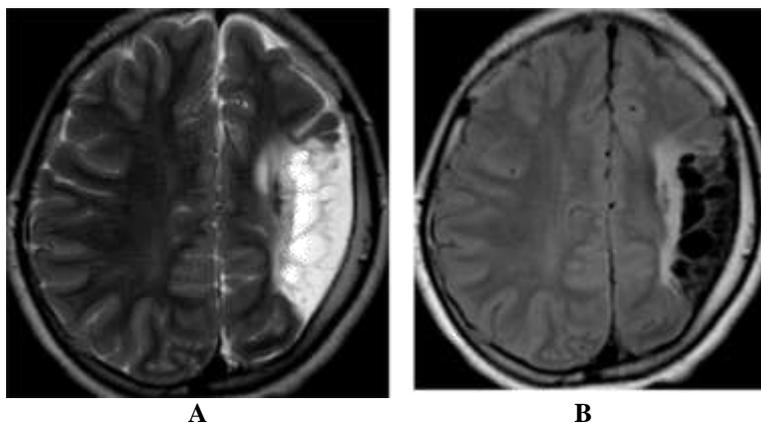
Perinatal insult in a 8 year old male. MRI showing cystic encephalomalacia in the left middle cerebral artery territory, which is hyperintense on T2 W (A) and suppressed on FLAIR (B) images with a peripheral hyperintense rim.
